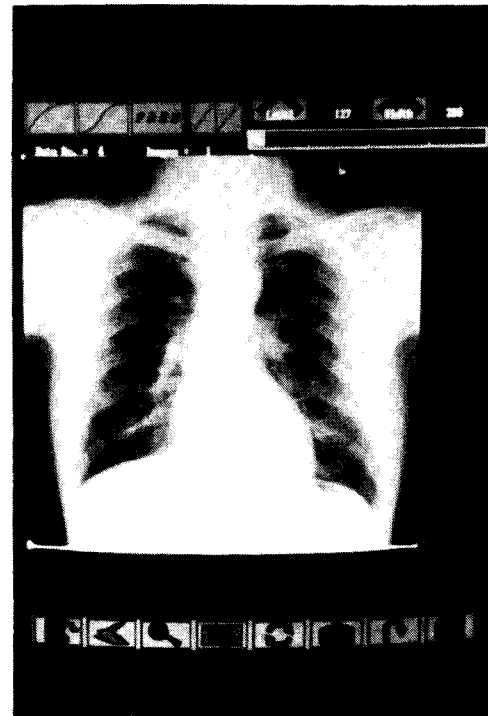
An Display Example of Radiography
